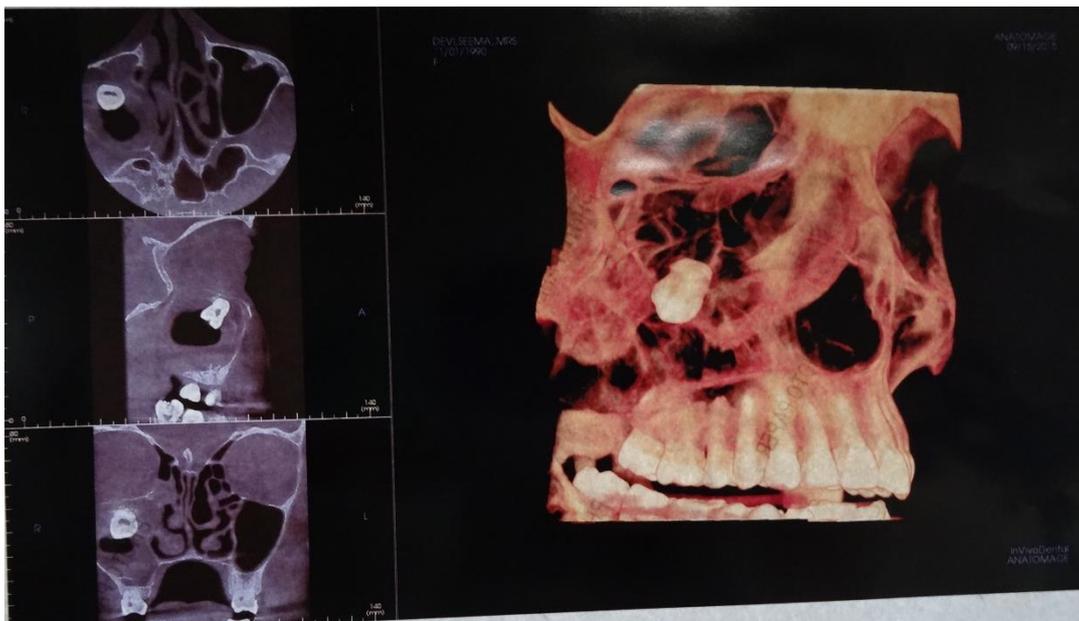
CBCT showing location of an ectopic tooth in right maxillary antrum below the floor of orbit
